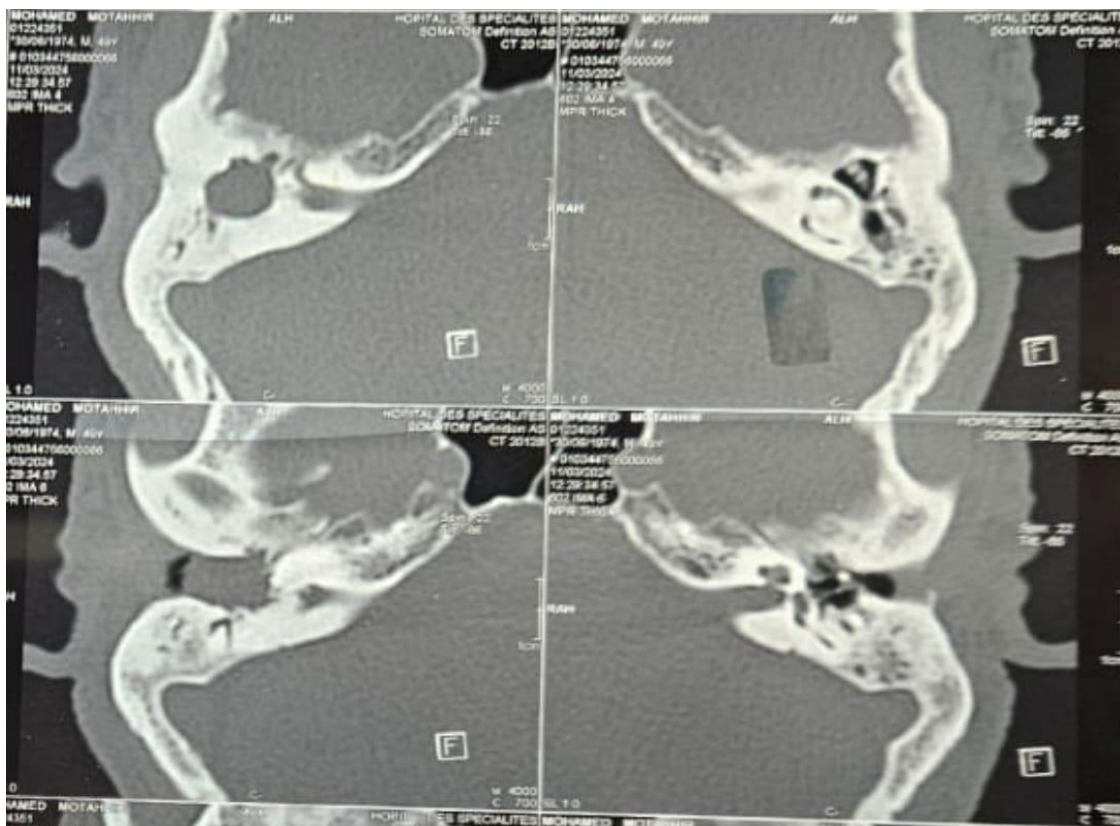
Axial CT scan showing complete absence of the cochlea, vestibule, and semicircular canals on the right side, consistent with ipsilateral Michel aplasia
